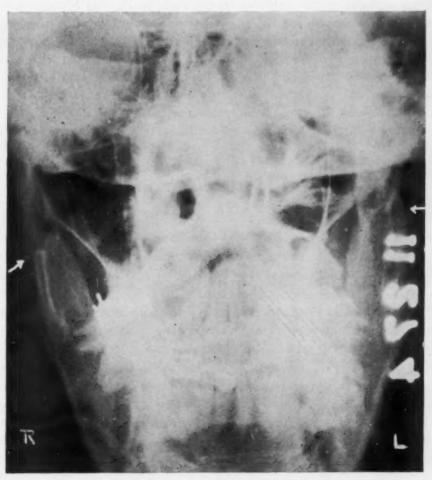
X-ray showing site of osteotomy in the ascending ramus performed one year previously at another hospital.
